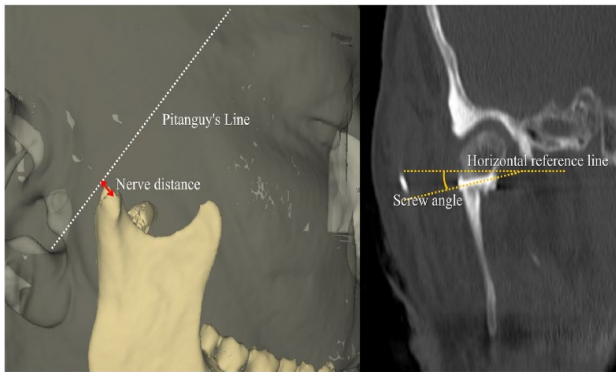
Methods for measuring nerve distance and screw angle. Nerve distance is determined as the shortest distance from the Pitanguy's line, a line extending from 0.5 cm below the tragus to 1.5 cm above the lateral eyebrow, to the end of the condylar stump (red arrow). Screw angle refers to the angle between the horizontal reference line and the screw on the coronal view of postoperative CT images.
